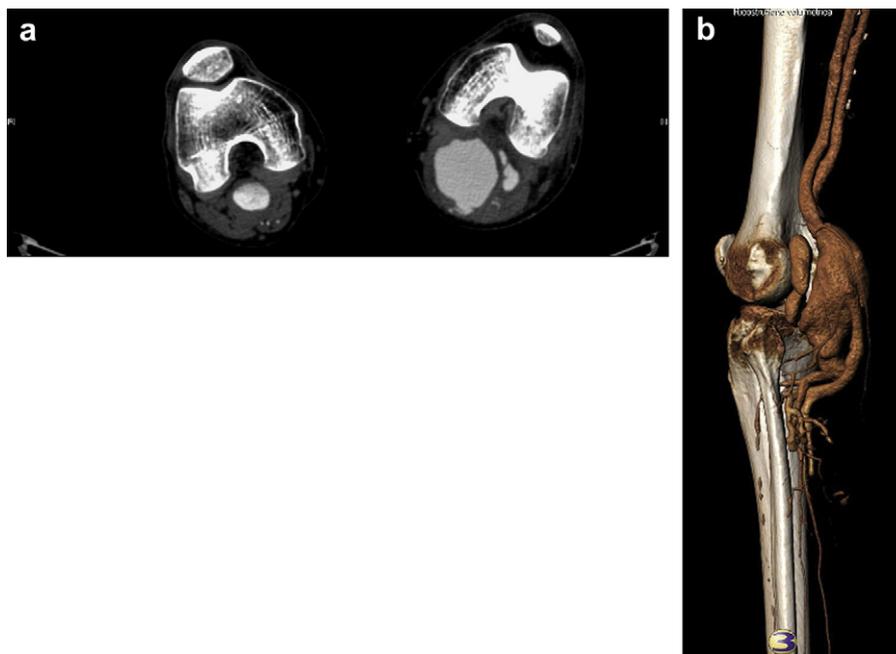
a, b: Preoperative CT angiography.
